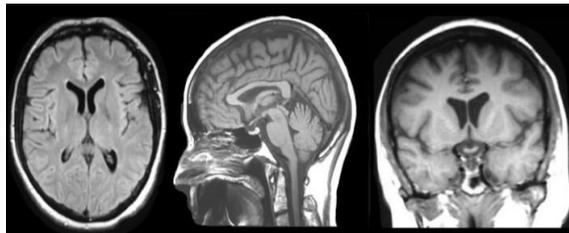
Brain MRI scan image, from left to right the axial, sagittal and coronal slice images scan.
